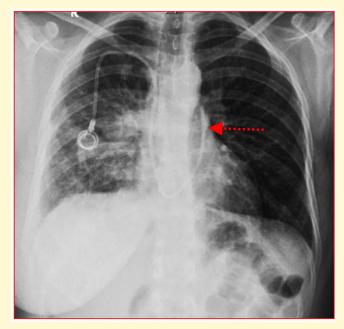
Frontal Chest Radiograph showing Chemoport in Main Pulmonary Artery.
